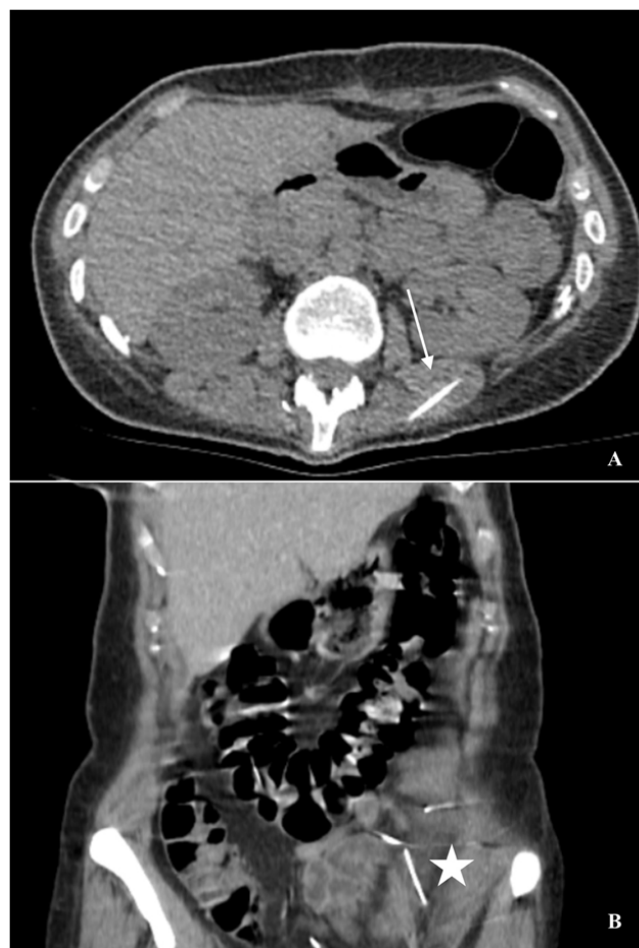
Case 1. On axial computed tomography (A) sewing needle (white arrow) is shown in erector spinae muscle and on coronal computed tomography (B) there are also sewing needles in left lower quadrant (white star) six months ago
